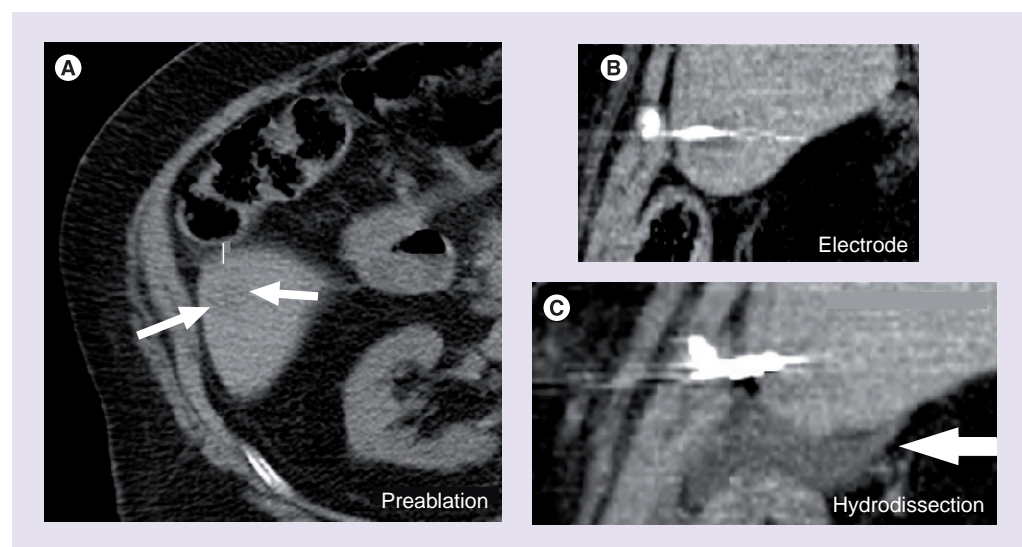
Protective hydrodissection allows ablation with clear margin without injury to the adjacent colon. (A) Preablation noncontrast CT demonstrates a low-density lesion in the right inferior hepatic lobe (white arrows). The liver in this region is nearly adjacent to the hepatic flexure of the right colon (white line). (B) Post-electrode placement CT again demonstrates close proximity of the right colon to the liver. (C) After hydrodissection, the colon is pushed away by fluid density infusate (white arrow), allowing for safer ablation.
